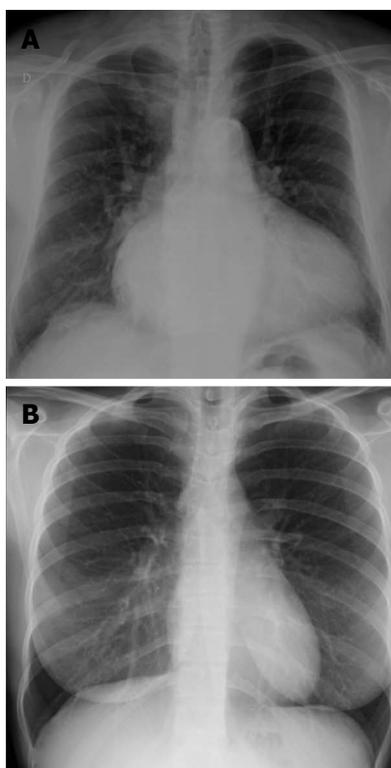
Posterior-anterior chest X-ray demonstrating enlargement of atrial and left ventricles, with redistribution of lung circulation from bases to apex suggestive to pulmonary congestion (A), note the blood vessels are more prominent in the upper lung fields compared to the lung bases, just the opposite of normal (B).
